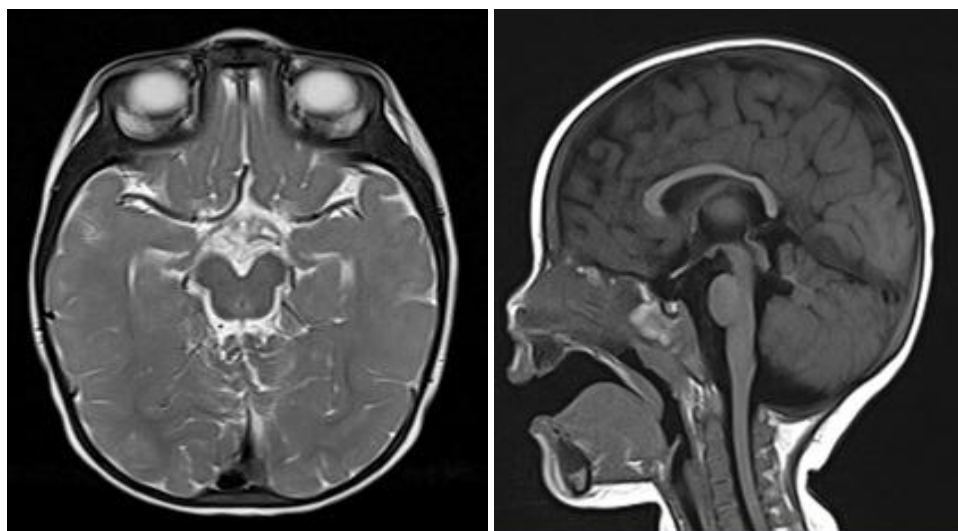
Axial and sagittal MR images showing deepening of interpeduncular fossa with rostral shifting of Fastigium.
